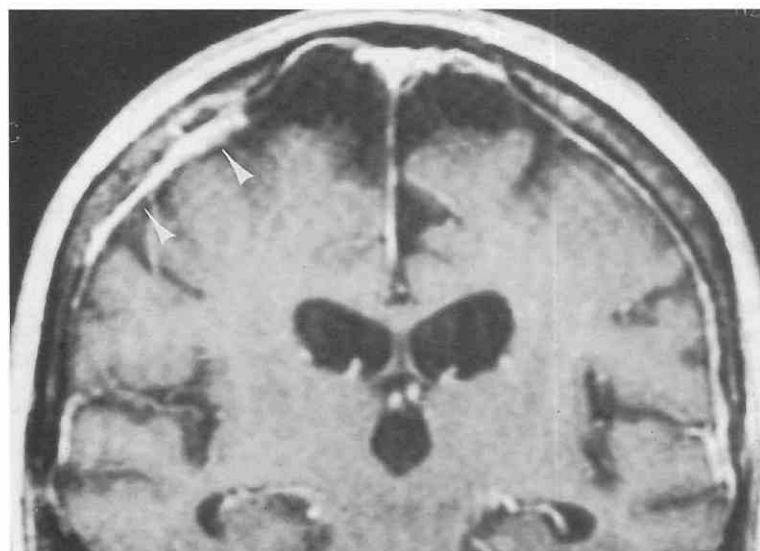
Focal, direct extension of breast carcinoma calvarial metastasis to dura. Coronal enhanced T1-weighted image shows focal dural thickening (arrowheads) and enhancement deep to a calvarial focus of breast carcinoma (see also Fig. 12-21).
